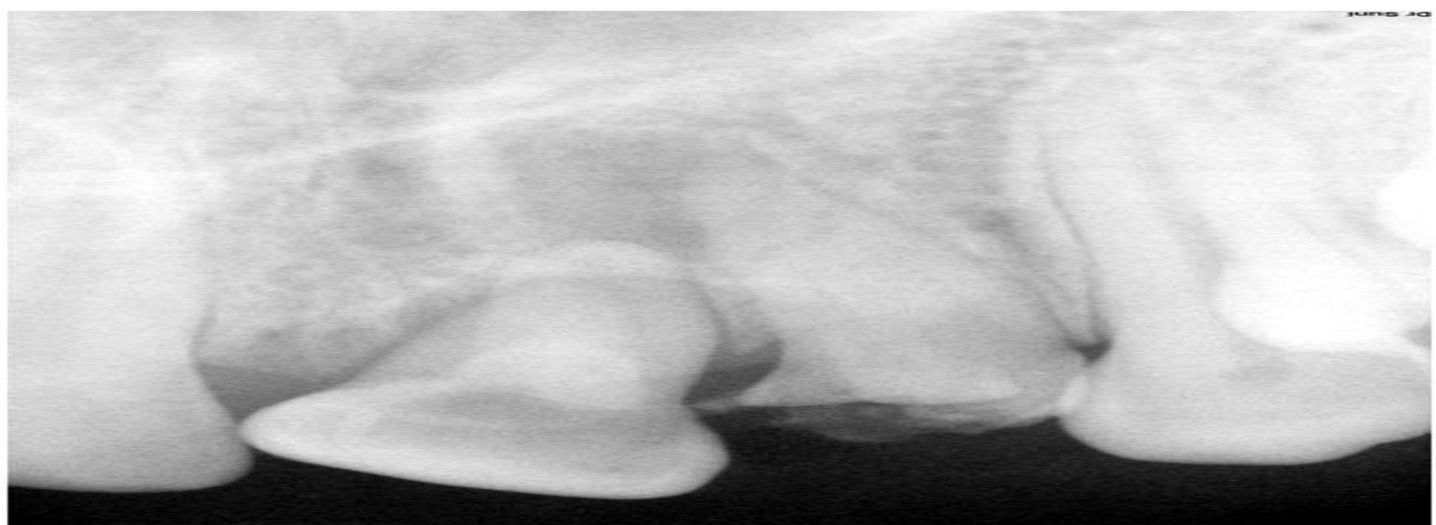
(a) IOPA with frontal angulation exhibiting periapical radiolucency with 21 (b) IOPA with mesial angulation showing double root with 21
